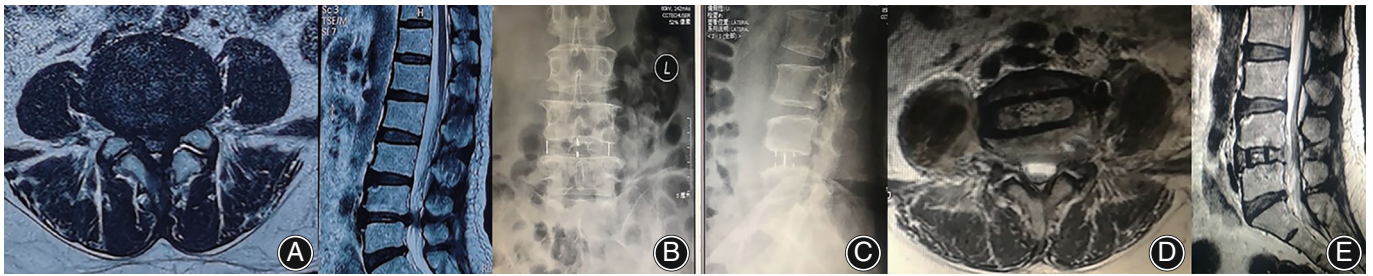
Case No. 1, female, 65 years old. (A and B) Preoperative MR T2-weighted images showed obvious L4/5 disc herniation and spinal stenosis; (C and D) anterior–posterior and lateral fluoroscopy after OLEDIF showed good cage position and normal lumbar sagittal alignment; (E) postoperative MR T2-weighted images showed good spinal canal decompression and dural sac expansion
